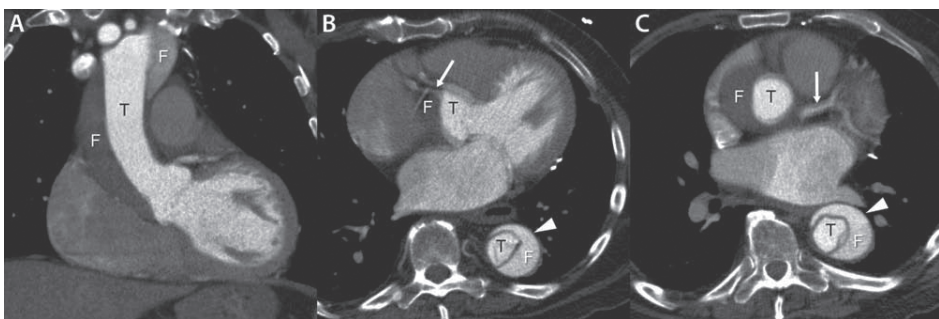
Thoracic CT angiography showing a type A aortic dissection(A).
